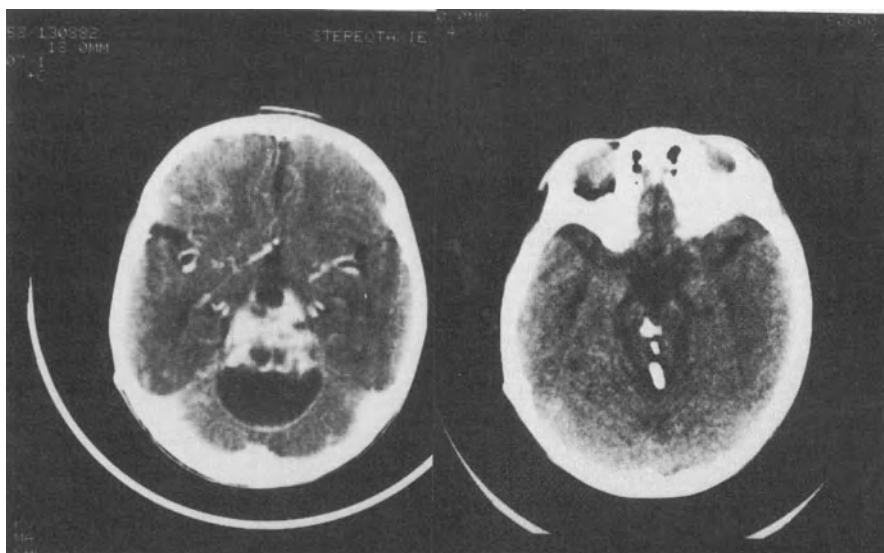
This 3½-year-old patient had a grade I pilocytic astrocytoma with a large cyst, which occupied the cerebellar vermis. (*Left*) A CT scan before Curietherapy demonstrated a 4-cm superior brain-stem tumor with intense contrast enhancement. (*Right*) A CT scan was performed 11 months after ^{125}I Curietherapy and stereotactic cyst implantation with a catheter and reservoir. Three consecutive cyst aspirations were performed. The ^{125}I sources are seen in the center of the tumor. The basal cisterns have reopened and cerebellar sulci can be recognized. The tumor no longer is evident. These findings were associated with dramatic clinical improvement and good physical development.
